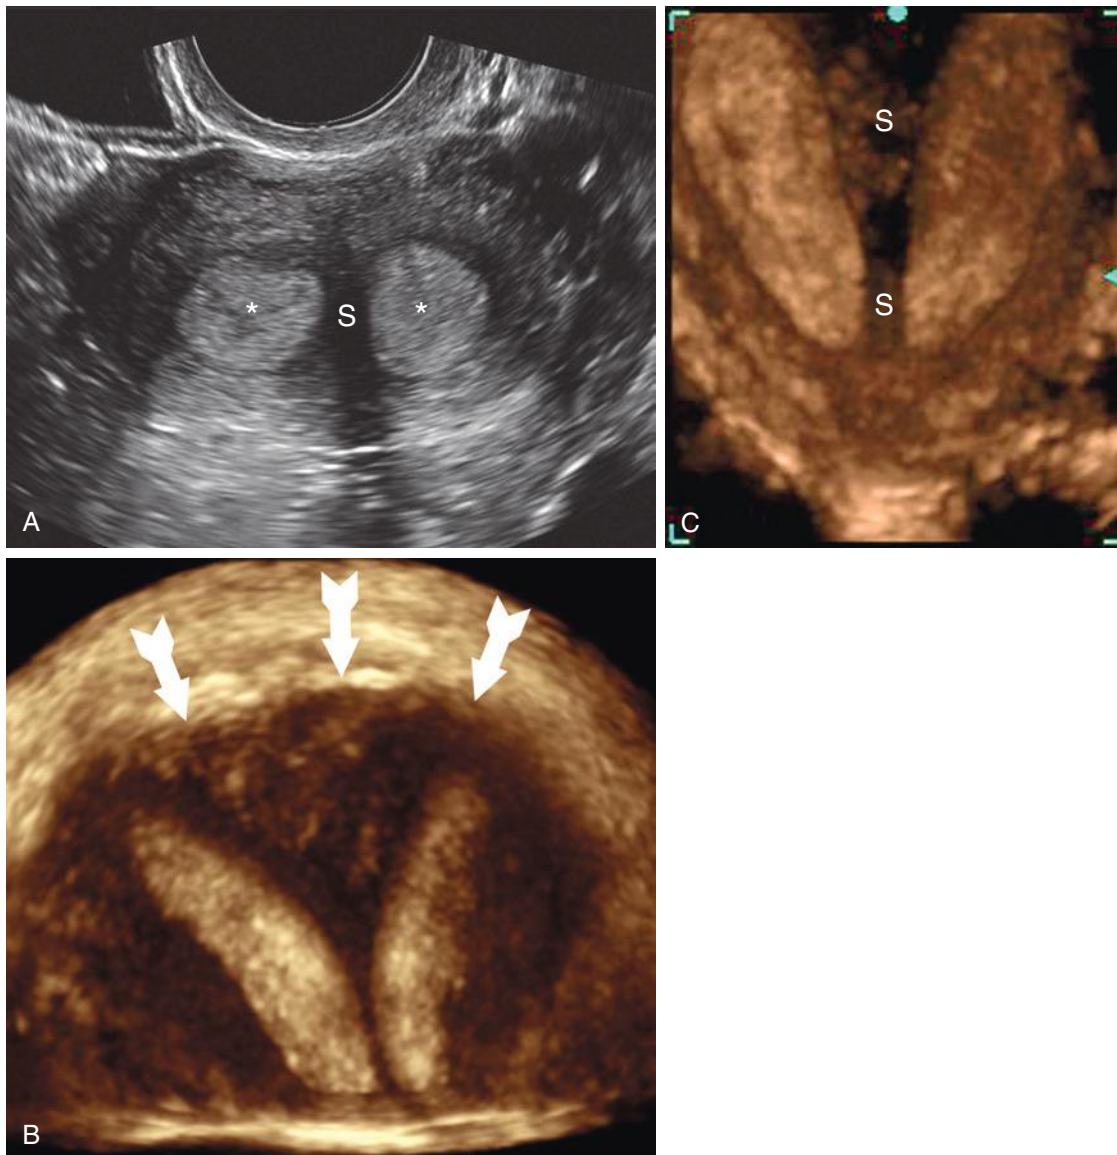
Three different patients with septate uterus. A, Two-dimensional (2D) transverse transvaginal ultrasound image shows two portions of the divided endometrial cavity (*asterisks*) with intervening hypoechoic septum (S). B, Three-dimensional (3D) sonographic coronal display of a septate uterus demonstrating the important feature used to distinguish this type of anomaly from a bicornuate uterus. Note the preserved, outwardly convex, smooth external uterine contour (*arrows*). C, 3D ultrasound coronal image shows the dividing uterine septum (S) extending from the fundus caudally to the cervix.
